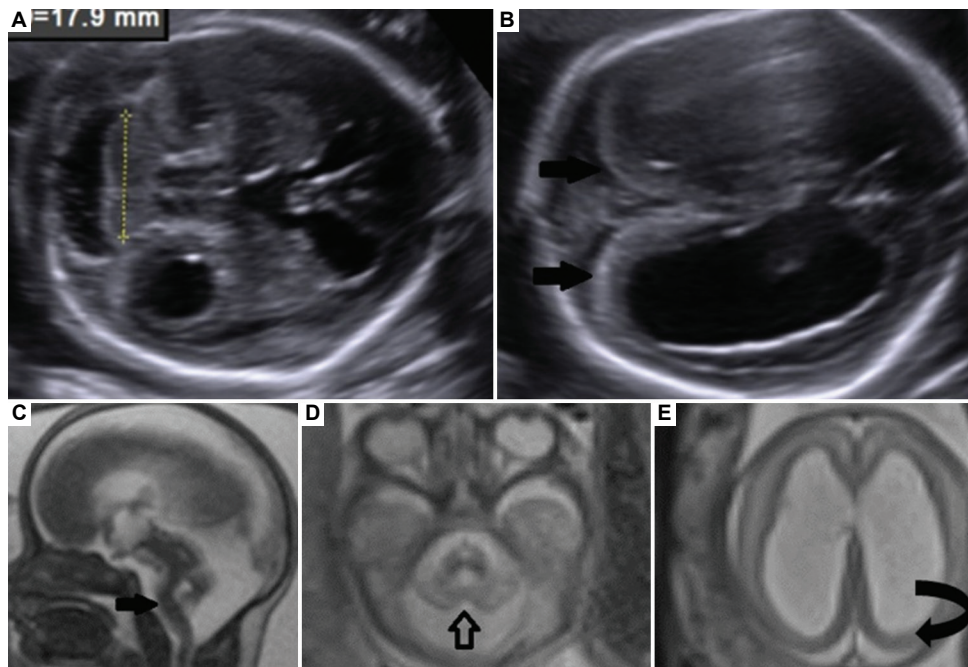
MRI and ultrasound images of a 22-week fetus. (A and B) Axial ultrasound images demonstrate a small cerebellum (yellow dotted lines), ventriculomegaly, and cobblestone lissencephaly (black arrow). (C-E) Sagittal TRUFI and axial HASTE images show kinked pontomesencephalic junction (black arrow) and a small vermis (black outlined arrow), which correspond to the ultrasound findings of a small cerebellum, ventriculomegaly, and cobblestone lissencephaly (black curved arrow).
